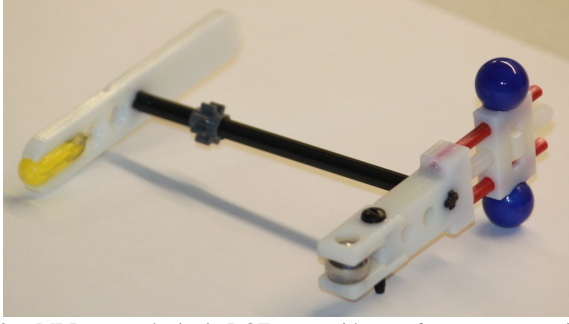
MRI-powered, single-DOF rotor with gear for power transmission.
